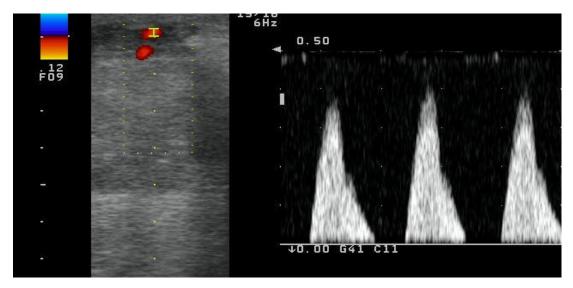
Infiltrating duct carcinoma in a 49 year old patient. The Doppler spectral waveform has the following indices – PI: 4.04; RI: 1; PSV: 47.5 cm/s; EDV: 0 cm/s. This malignant mass has very high PI (greater than 4) and very high RI (equal to or greater than 1).
